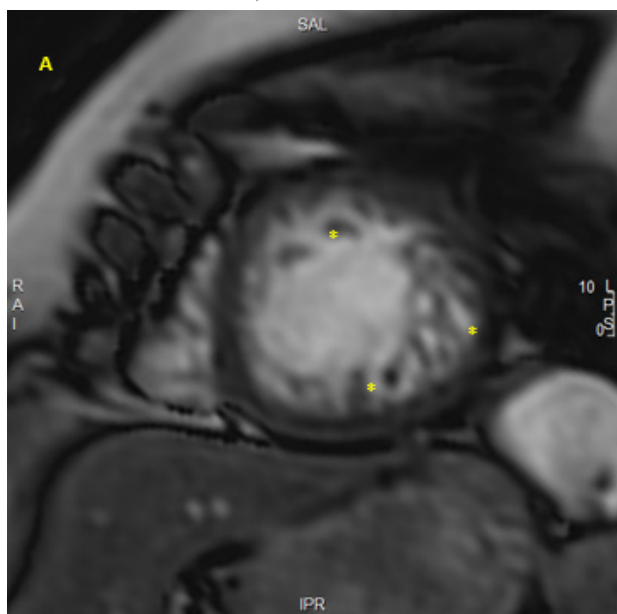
MRI apical short axis image at end-diastole 2023 showing trabeculations (asterisk) and decreased systolic function.
